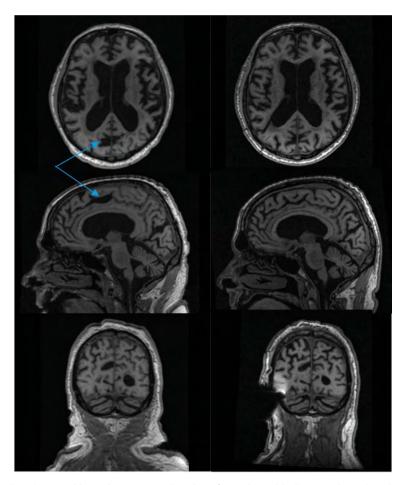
Post-shunt imaging changes. Magnetic resonance imaging of a patient with disproportionately enlarged subarachnoid hydrocephalus (DESH) who underwent ventriculoperitoneal shunting. *Left* images were acquired three days prior to shunting and demonstrate ventriculomegaly and sulcal trapping (blue arrows). *Right* images were acquired 33 months after shunting, and show shunt, decreased ventricular size, and reduced size of extraventricular cerebrospinal fluid pockets
